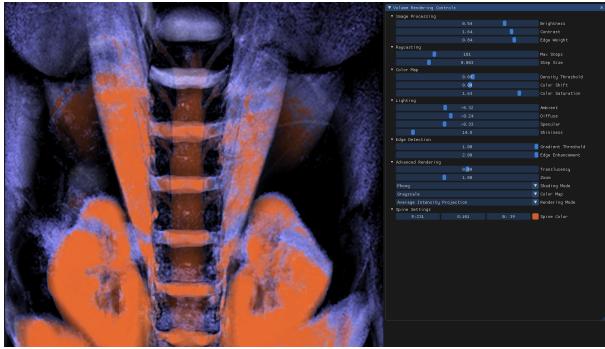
Average Intensity Projection (AIP) of CT Scan
